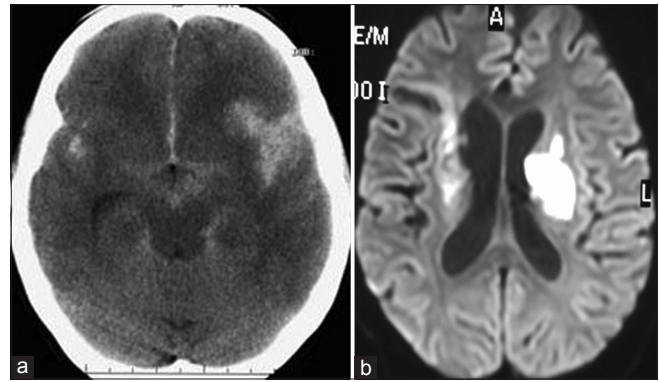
(a) Preoperative computed tomography scan showing the left middle cerebral artery aneurysmal bleed. (b) Diffusion-weighted imaging showing diffusion restriction
